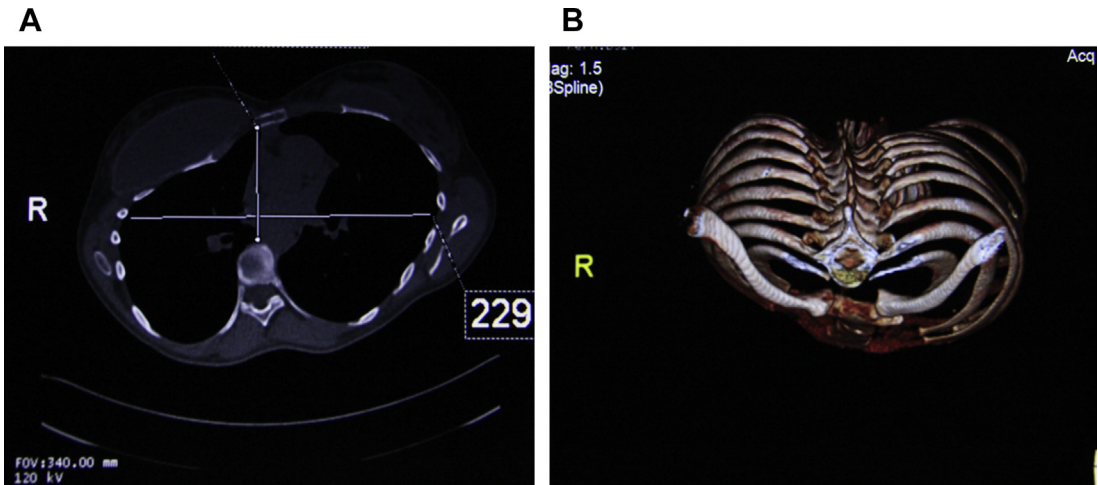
(A, B) 22-year old with Marfan syndrome. Preoperative CT scan demonstrates severe chest wall deformity and presence of 2 asymmetric round gel implants. 3-dimensional CT reconstruction demonstrates significant chest wall asymmetry.
